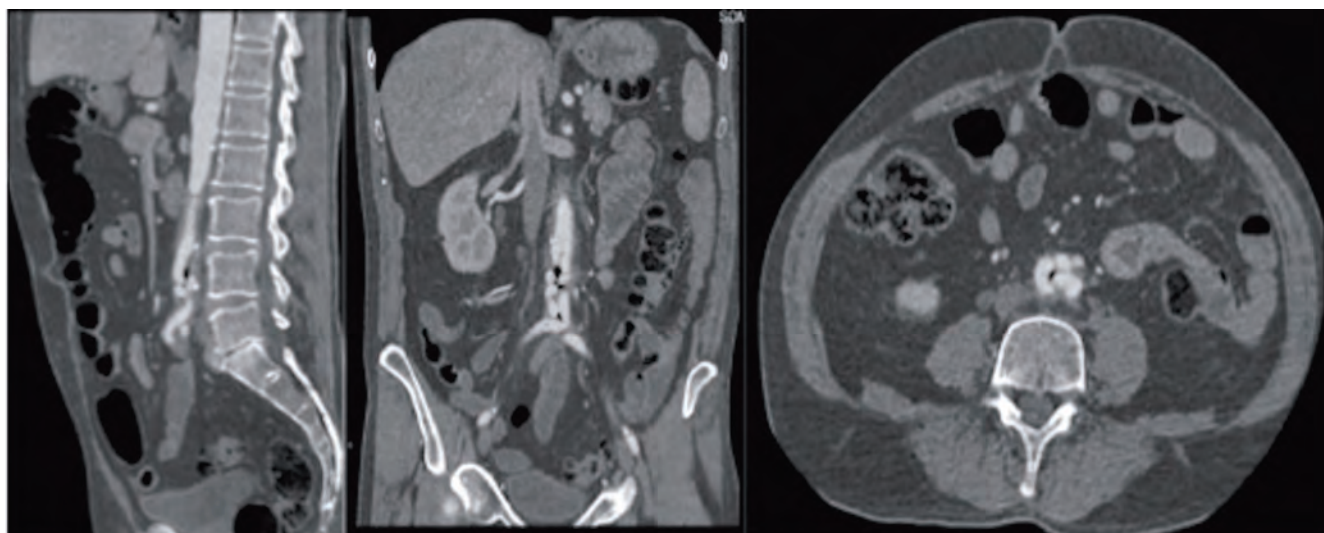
Abdominal CT shows aortic endoluminal gas in the region of vascular prosthesis.
